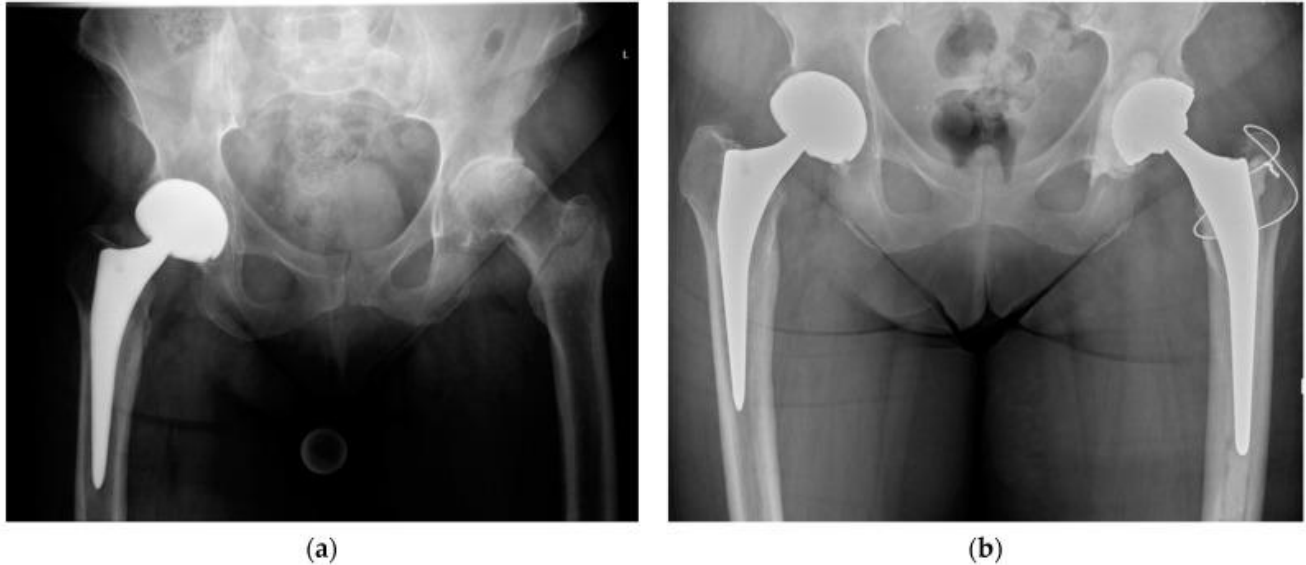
(a) Preoperative anteroposterior pelvic radiograph of an intertrochanteric femur fracture with concomitant osteoarthritis of the left hip; (b) postoperative anteroposterior pelvic radiograph after total hip arthroplasty with a cemented femoral stem, fixation of the greater trochanter by a figure-of-eight wire cerclage, and a cemented acetabular cup.
